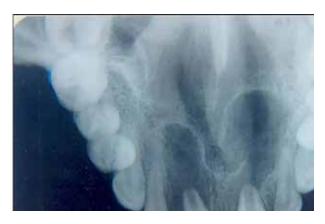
Standard maxillary occlusal radiograph showing the extent of radiolucency in the periapical aspect of teeth 11 and 21.
